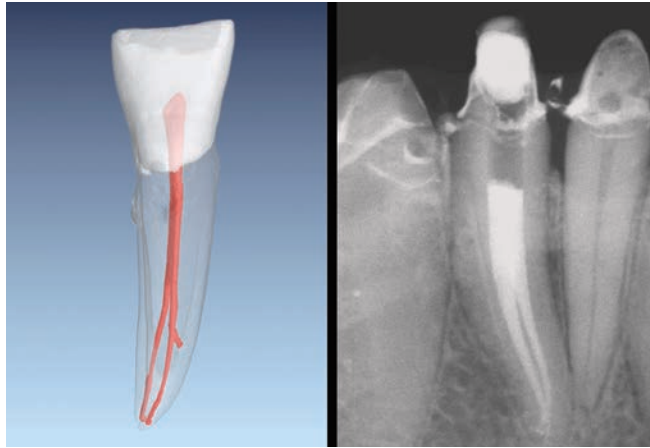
A μ CT image of a mandibular incisor (courtesy of Dr. Frank Paque; Zurich, Switzerland). This radiograph reveals an abutment tooth with similar anatomy.
